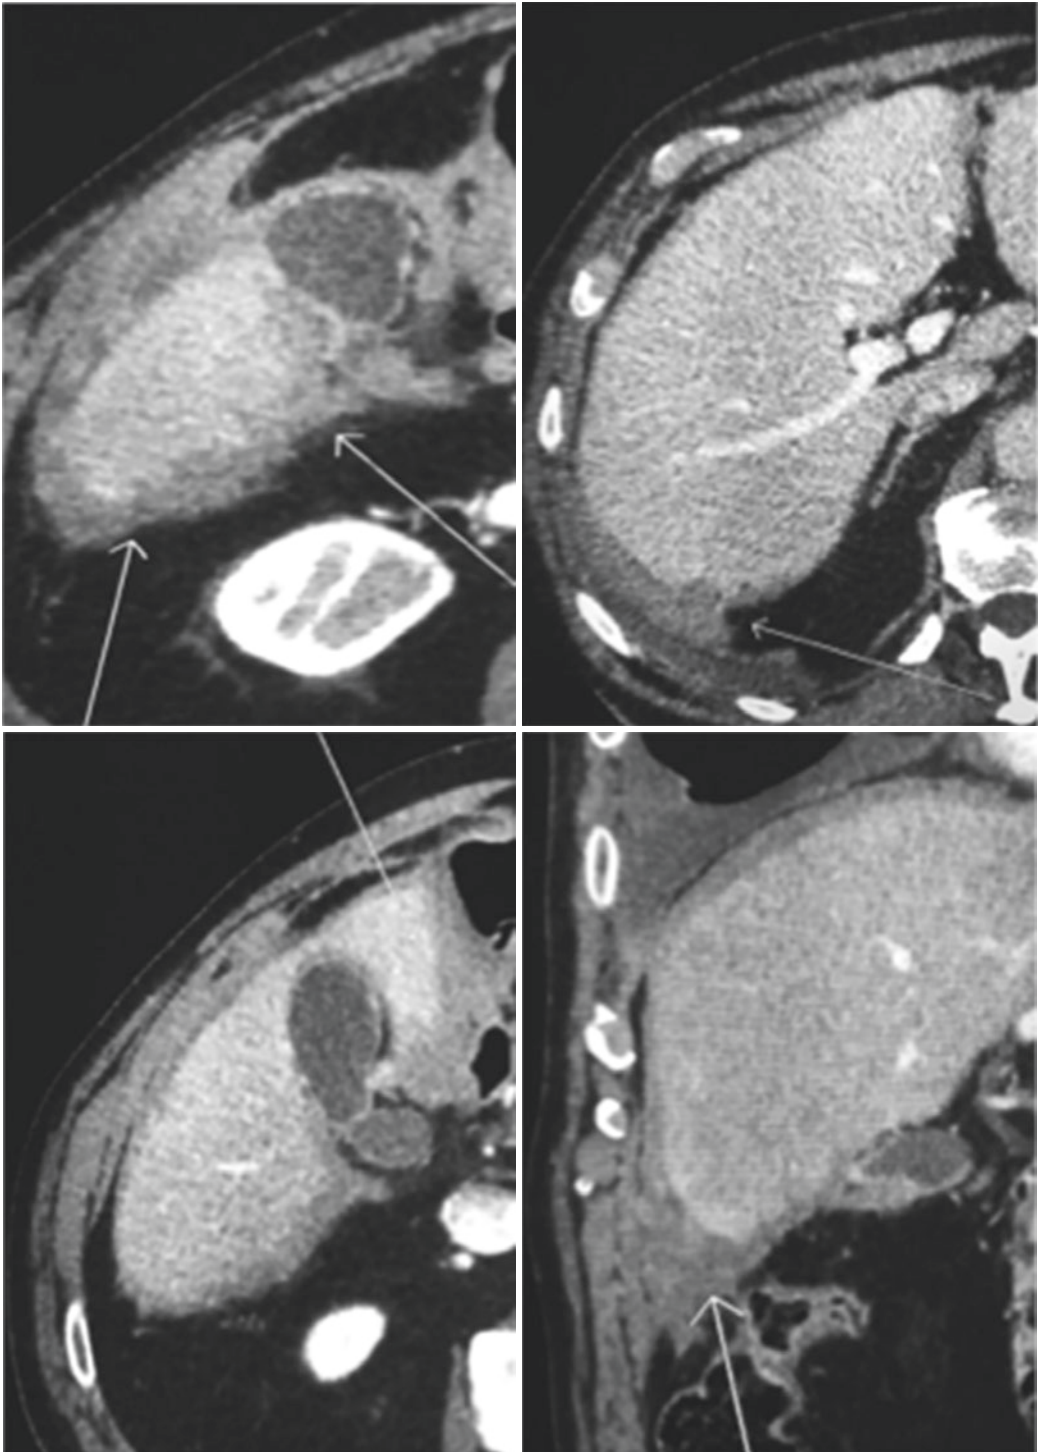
CT imaging of a mesothelioma arising from Glisson's capsule
